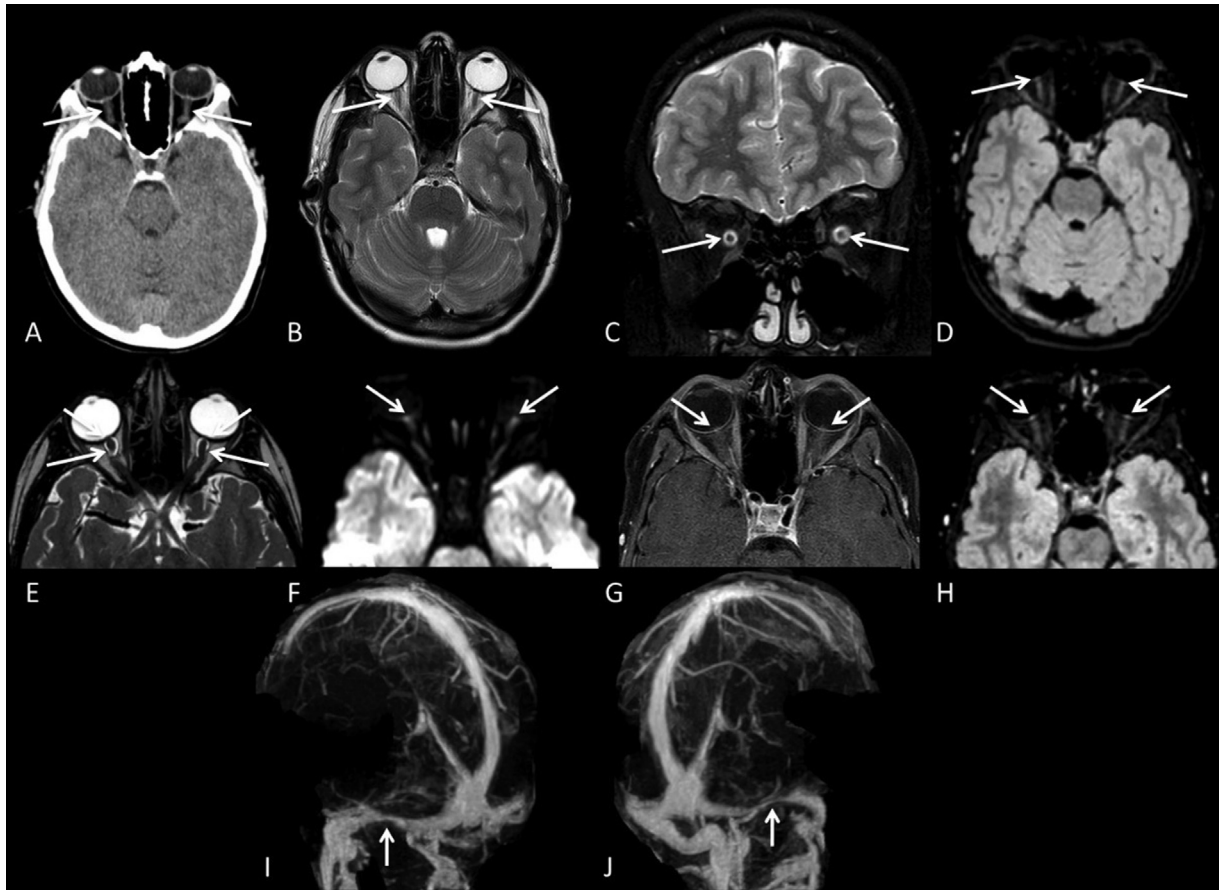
(A) Computed tomography (CT) without contrast revealing cerebrospinal fluid (CSF) distension of the optic nerve sheath (white arrows). (B,C) T2-weighted axial and coronal sequences again showing CSF distension of the optic nerve sheath (white arrows). (D) Fluid-attenuated inversion recovery (FLAIR) weighted axial sequence revealing hyperintensity of the optic papilla (red arrows). (E,F,G,H) T2 driven equilibrium (DRIVE), diffusion-weighted imaging (DWI), T1 postcontrast and FLAIR postcontrast sequences to assess orbits provide a clearer view of the CSF sheath distension (blue arrows) and signs of bilateral papilledema (red arrows), displaying hyperintensity in diffusion sequence, postcontrast intensity on T1 and FLAIR, with the latter providing greater sensitivity. (I,J) Magnetic resonance angiography showing bilateral stenosis at the transition between the transverse and sigmoid sinuses (green arrows).
